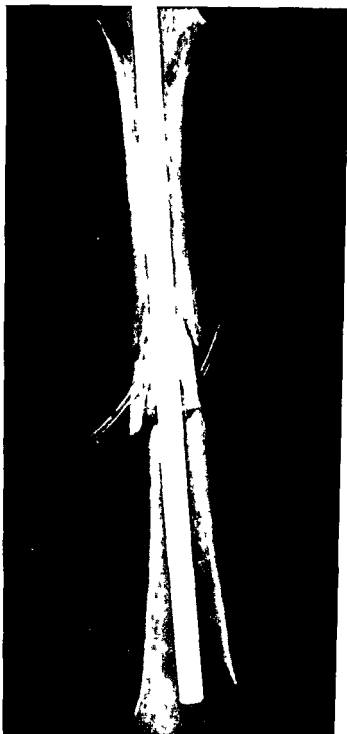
Radiograph of a fractured femoral shaft with an intramedullary nail in place. Infection is present with necrosis of a section of the shaft. Through and through irrigation is being used. In the presence of infection it is probably wise to remove all metal. Metal prevents the encroachment of living tissues and keeps an abscess space open all along its borders.
